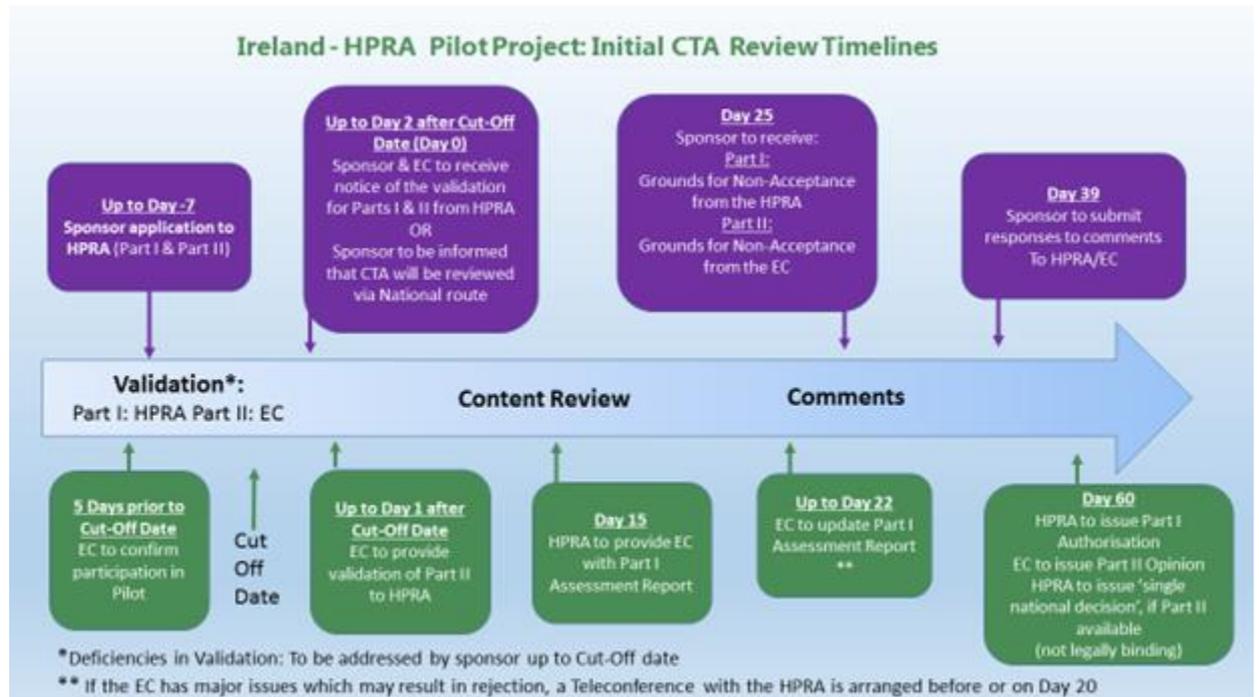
Ireland - HPRA pilot project: initial CTA review timelines
